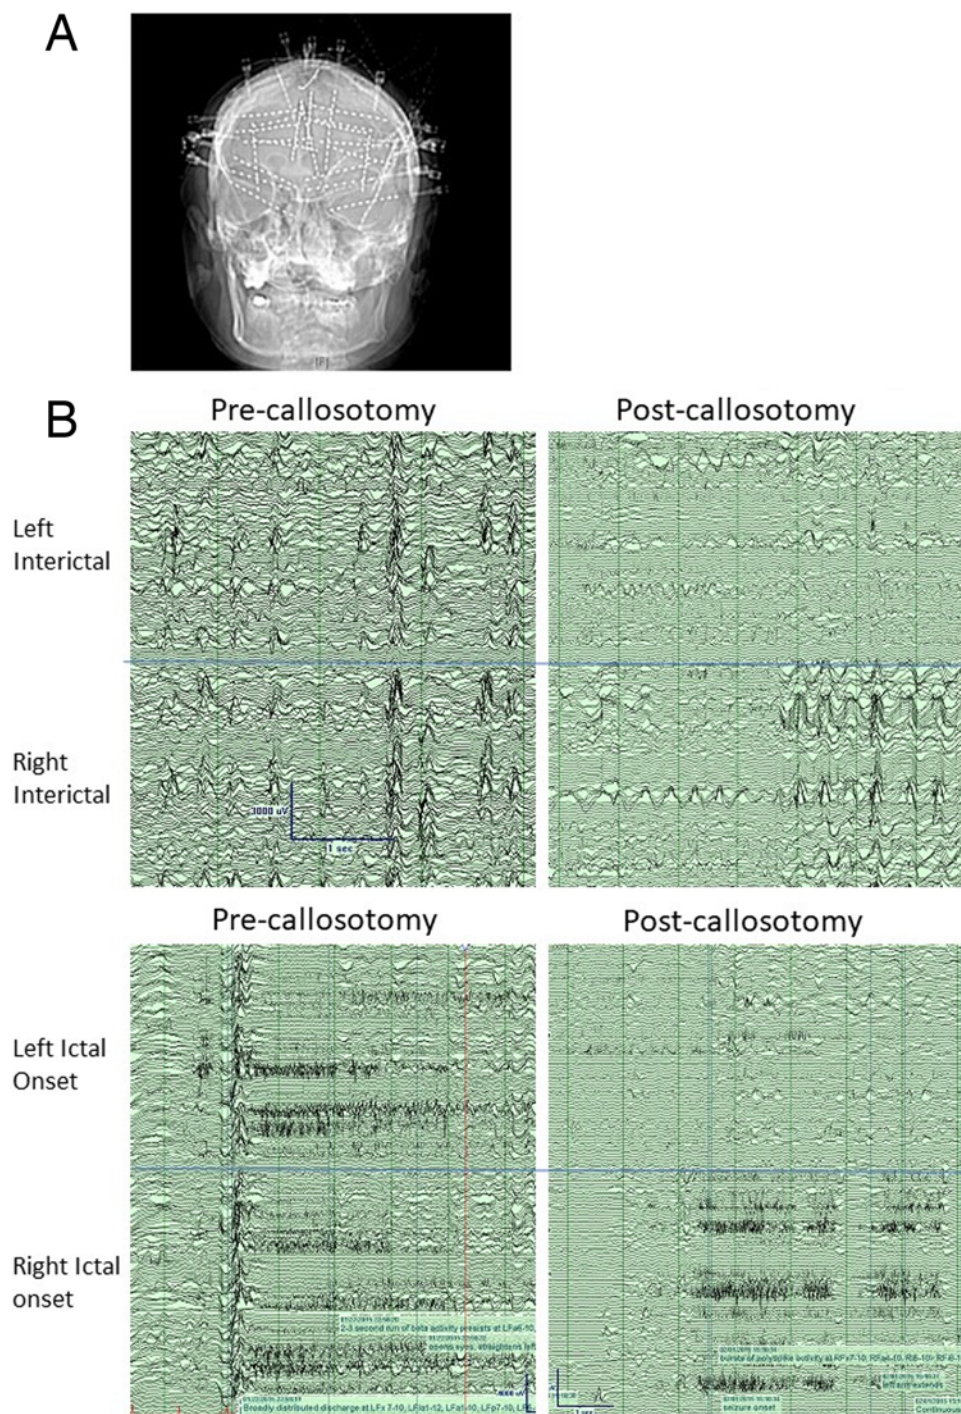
A: Representative anteroposterior skull radiograph obtained in case 1, showing placement of SEEG depth electrodes. B: Interictal and ictal EEG obtained in case 1 showing rapid generalized seizure activity precallosotomy and lateralization of the seizure to the right hemisphere postcallosotomy. Figure is available in color online only.
